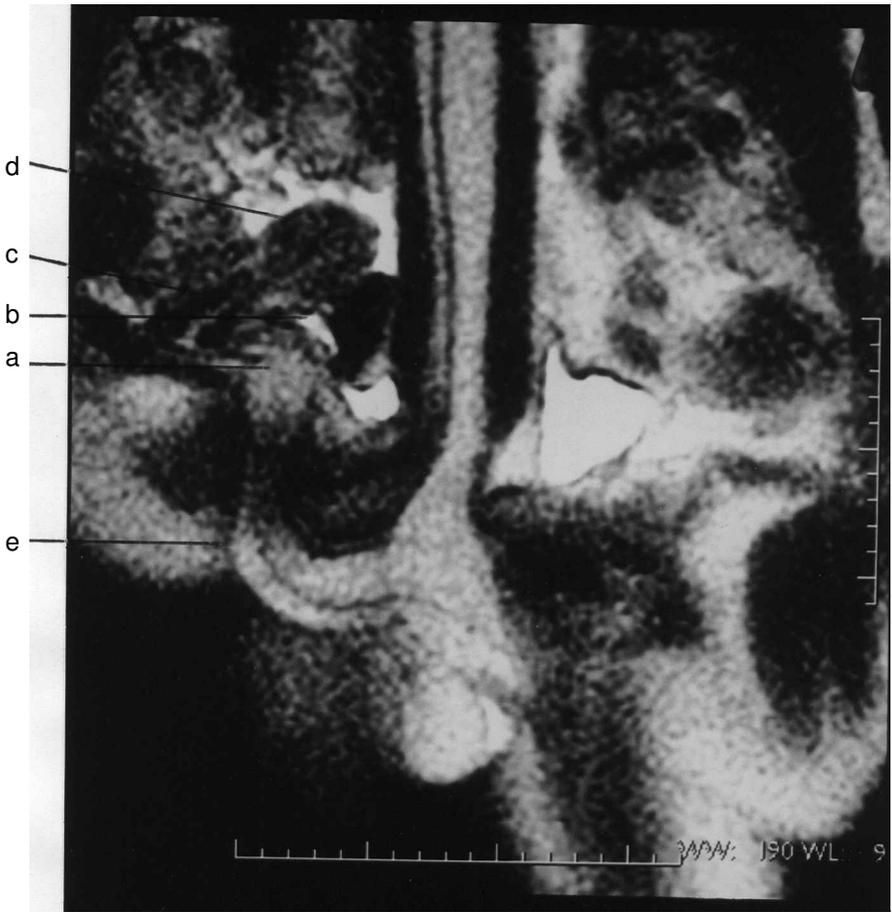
MRI photograph of third session, showing gland and anterior cul-de-sac (a), female bladder (b), cervix (c), uterus (d), and central node of the perineum (e).
